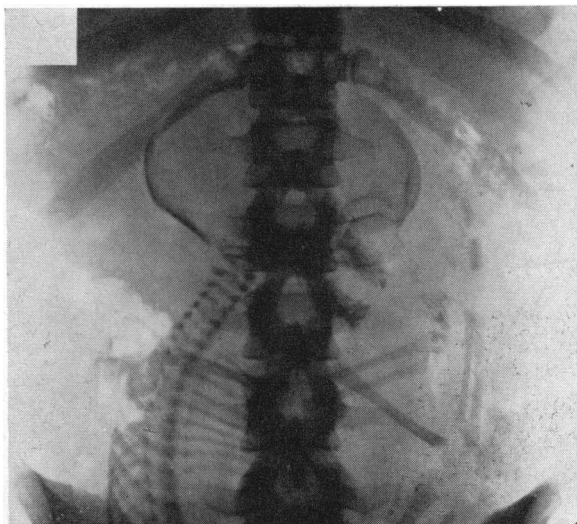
Roentgenogram taken four days after Figure 1 shows the fetal attitude of opisthotonos to have changed to one of flexion. The cervicodorsal spine is now well flexed, and the arms, previously extended, are now folded across the chest. The magnification of the head is diminished owing to patient being prone.
